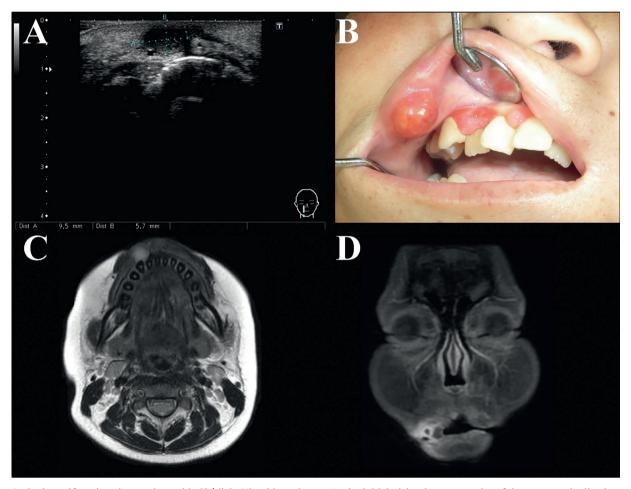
Oral manifestations in a patient with Chédiak—Higashi syndrome. At the initial visit, ultrasonography of the mass on the lip showed a relatively homogeneous hypoechoic appearance with a distinct border (A). Two weeks later, gingival swelling had reduced, but the lip swelling had progressed to an abscess (B). On magnetic resonance imaging, T2-weighted images showed a well-circumscribed cystic lesion surrounded by hyperintense signal halos (C); T1-weighted images showed contrast intensification around three cystic lesions reflecting the thick capsule (D).
